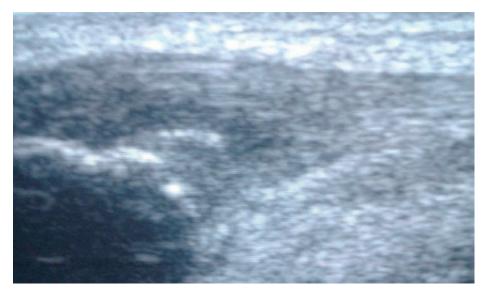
Ultrasound scan of Achilles tendinosis
